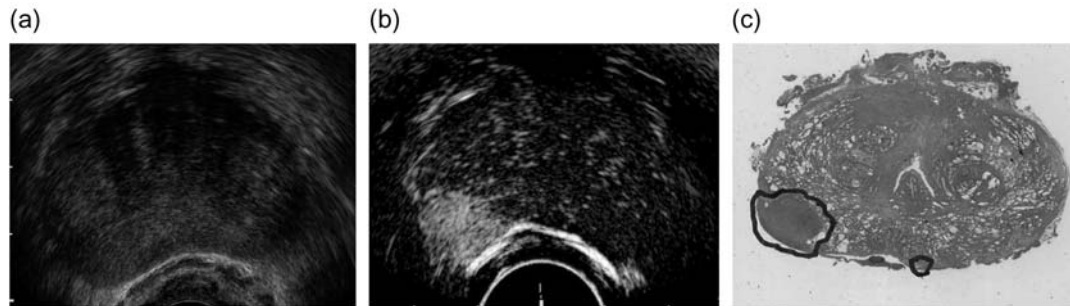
(a) A 74-year-old man with an elevated prostate-specific antigen (PSA) level of 8.2 ng/ml who had a palpable prostate nodule on the right lobe by rectal examination. Grayscale sonogram showed no focal lesion with hypoechoogenicity. (b) Contrast-enhanced sonogram showed strongly increased vascularity in the right lateral lesion, suggesting the presence of prostate cancer. (c) Pathological examination revealed that the tumor was a Gleason 4 + 3 adenocarcinoma with capsular penetration, which proved to be in agreement with the enhancement of the lesion.
